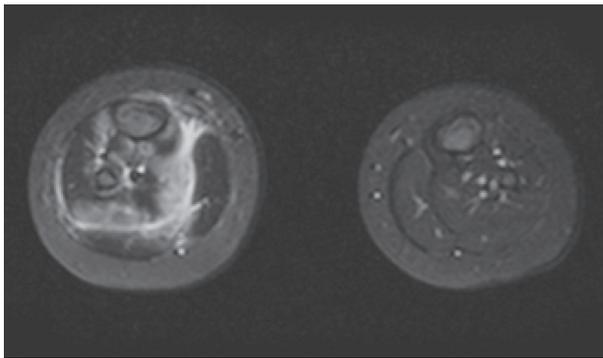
Axial T2-weighted fat-suppressed MR image of the lower legs. High signal intensity regions are seen in the gastrocnemius muscle and the fascia of soleus muscle of the right leg, suggesting inflammation.
